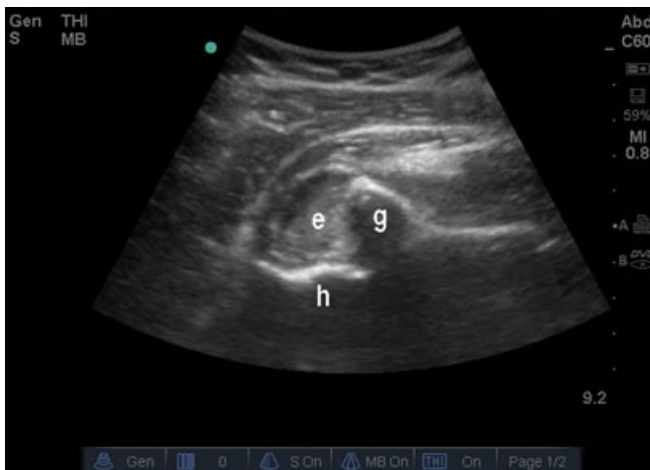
Ultrasound image obtained from posterior aspect of shoulder demonstrates glenoid (g), joint effusion (e) with hyper-echoic hemarthrosis, and anteriorly displaced proximal humerus (h).
